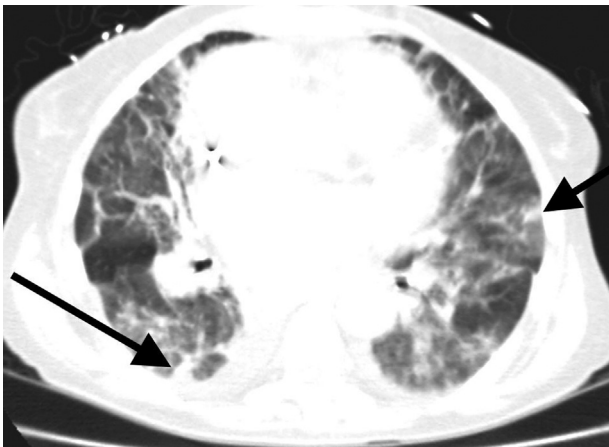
Amiodarone toxicity. Axial CT in lung window shows bilateral ground-glass opacities and interstitial disease (arrows). Note cardiomegaly in the setting of long-standing cardiac disease.
